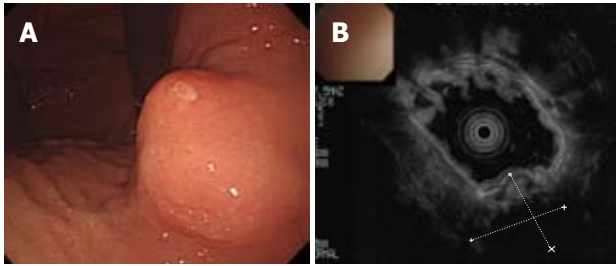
Endoscopy and endoscopic ultrasound of stomach. A: Endoscopic examination revealed a round submucosal tumor; B: The tumor originated from the fourth layer of the gastric wall as indicated by endoscopic ultrasound. The deeper section could not be visualized because of calcification.
